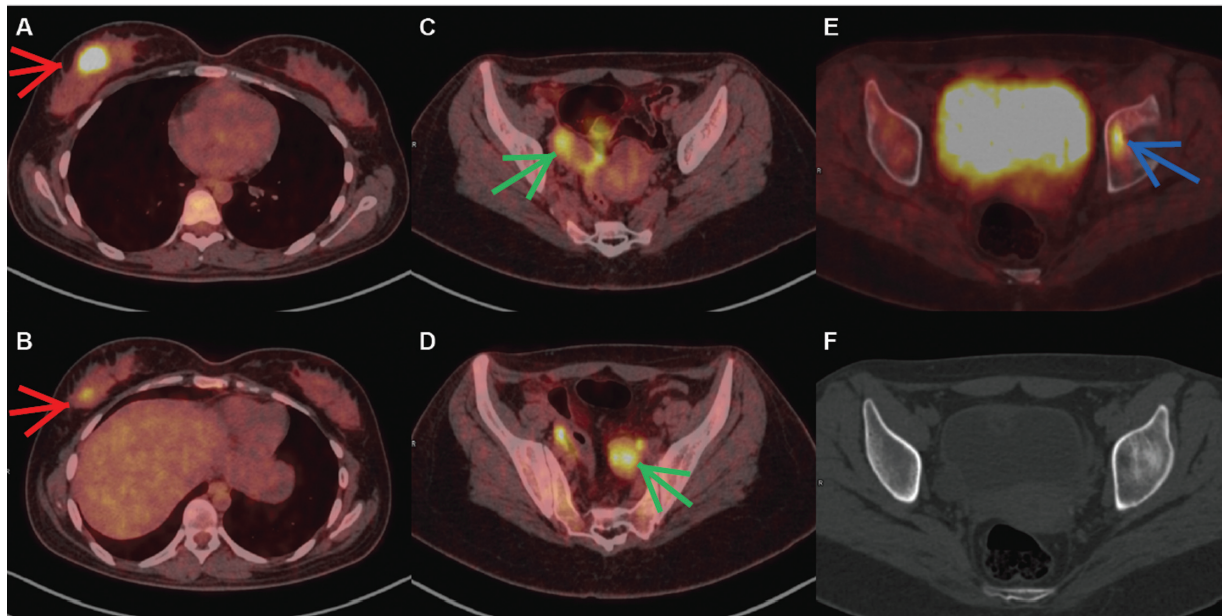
End-cycle response positron emission tomography/computed tomography (PET/CT) fused images reveal fludeoxyglucose (FDG) avid multiple lesions in the right breast (A, B); FDG avid lesions in the bilateral ovary (C, D), and FDG avid lesion in the left iliac bone (E) corresponding to axial CT image (F) reveal lytic lesions in the left iliac bone.
